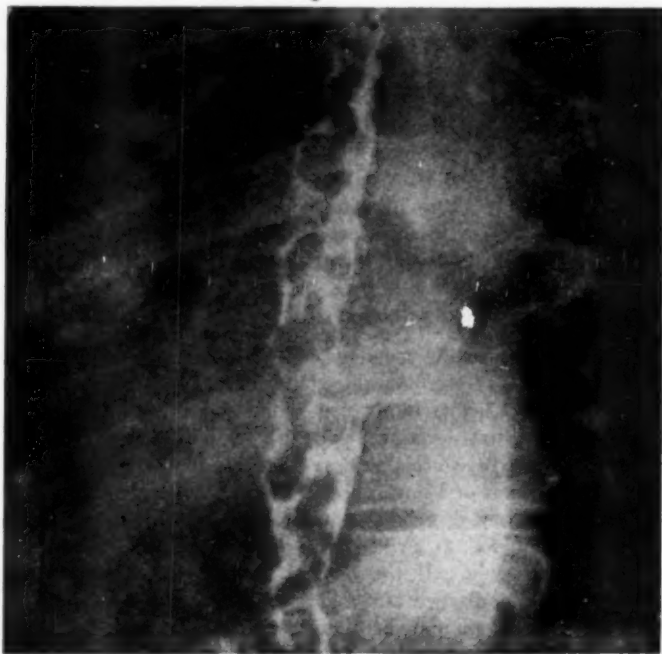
A reproduction of a roentgenogram of the esophagus demonstrating the esophageal varices in a patient with portal hypertension due to so-called Banti's syndrome. This diagnostic procedure affords the most positive diagnosis of portal hypertension.
